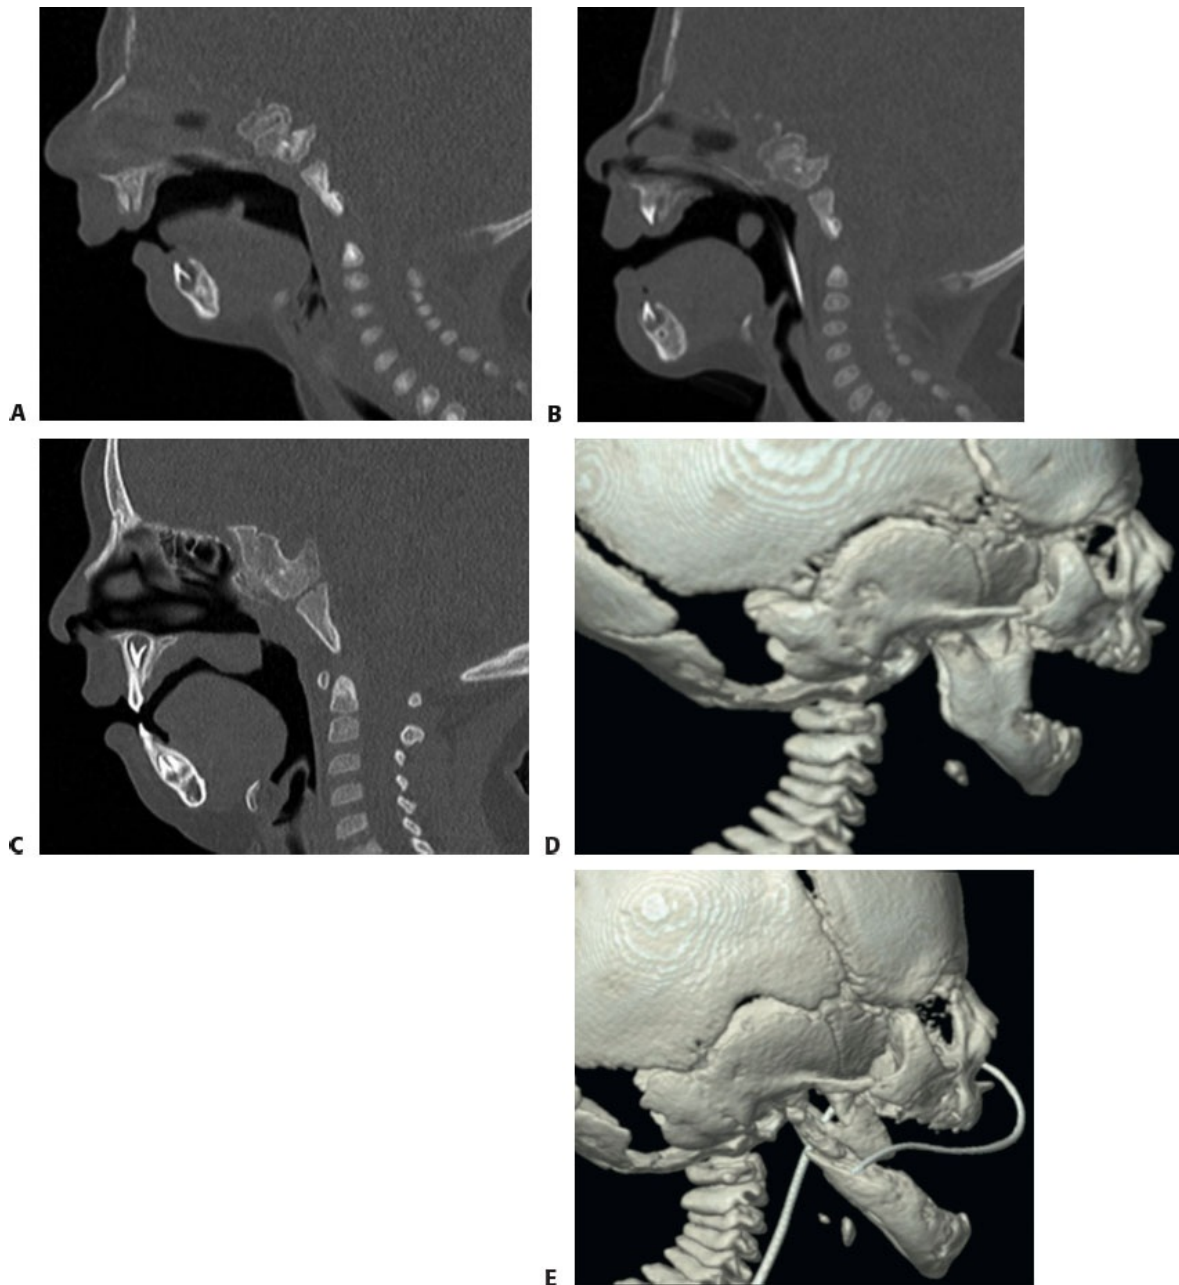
• A. Preoperative sagittal view CT scan demonstrating mandibular micrognathia and narrow airway. B. Airway improvement at the end of distraction, showing overcorrection. C. Two-year postoperative view demonstrating relapse, but with maintenance of airway clearance. D. Three-dimensional CT scan before distraction. E. Extent of mandibular advancement at the end of the distraction.
